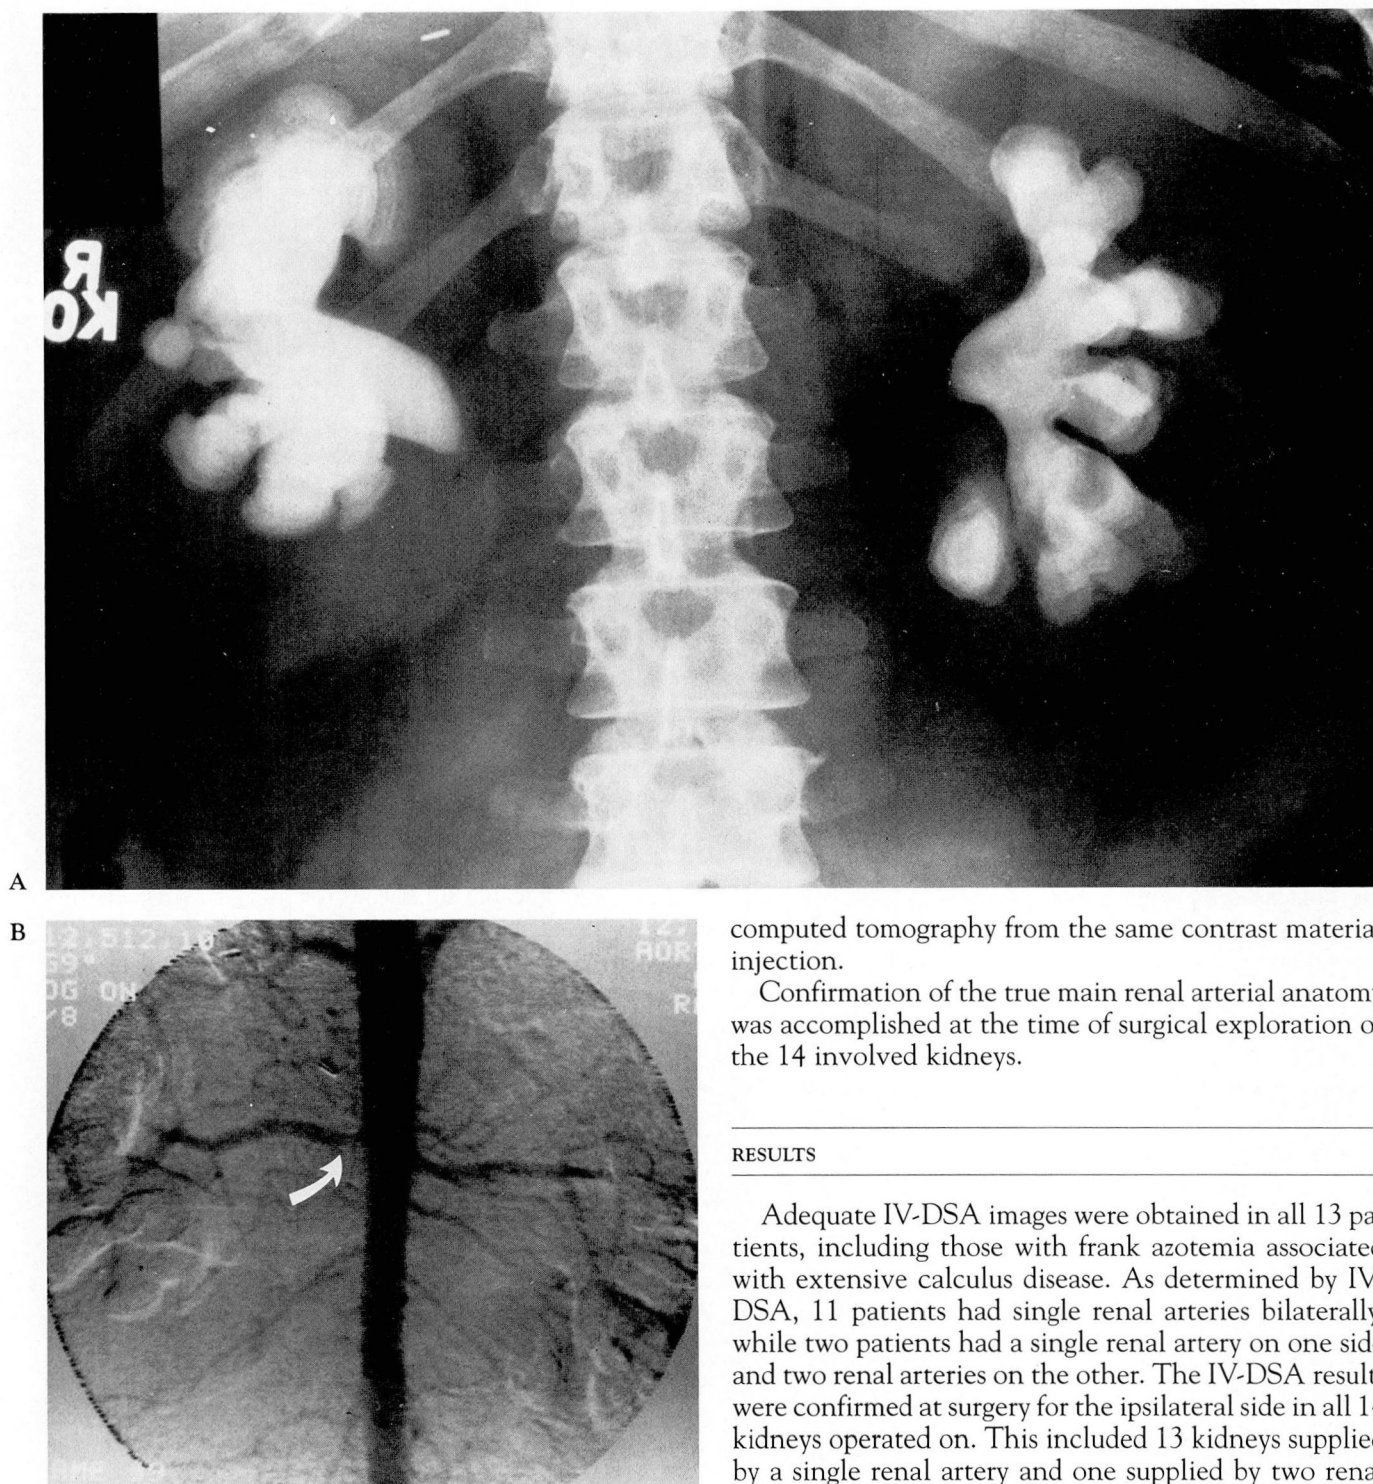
Scout radiograph demonstrates extensive bilateral staghorn calculus disease. FIG. 2B. IV-DSA demonstrates single renal arteries bilaterally (also noted is a 50% stenosis of the proximal right renal artery, arrow). Serum creatinine level was 3.1 mg/dL at time of this study.
